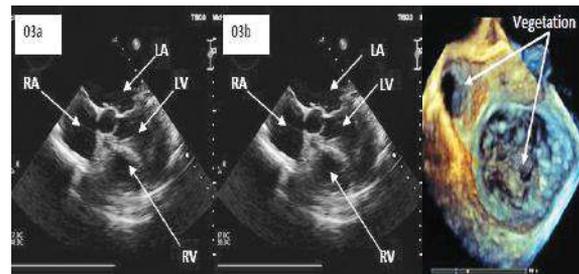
Multiple vegetations over mitral valves and atrial surface on 2D echocardiogram
